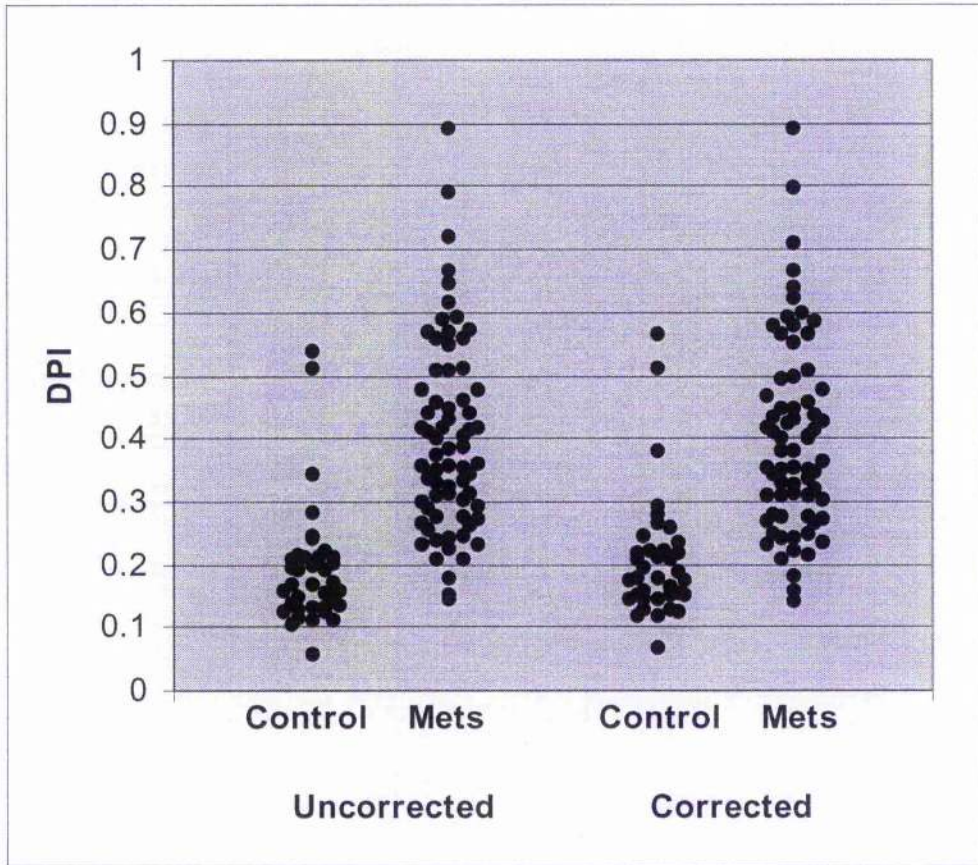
Distribution of Doppler Perfusion Index (DPI) in control subjects and patients with liver metastases, with and without age correction.
